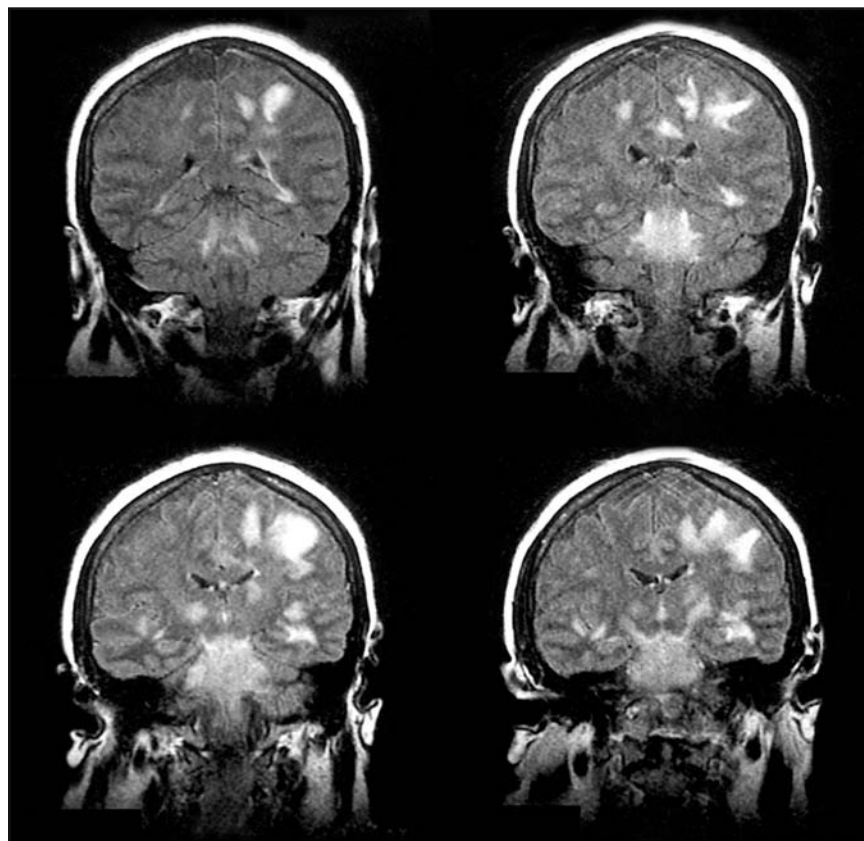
Coronal T2-weighted MRI of a patient with acute disseminated encephalomyelitis demonstrating areas of confluent demyelination.
